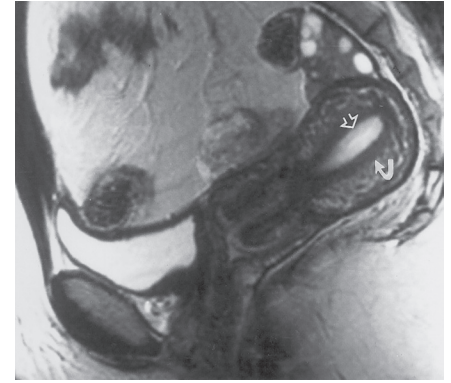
Normal reproductive age endometrium. T2-weighted MR image shows the normal endometrium (straight arrow) and junctional zone (curved arrow).
